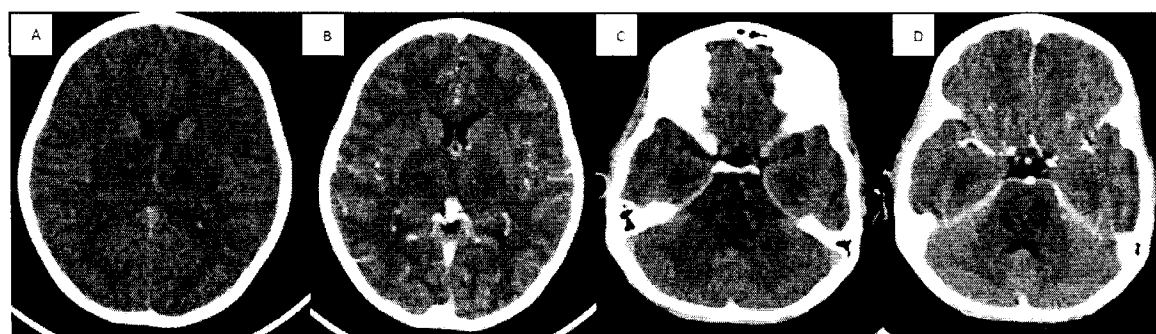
CT on Day 5th of illness showed ill-defined symmetrical non-enhancing hypodensities in both thalami and pons (A, B, C and D)
